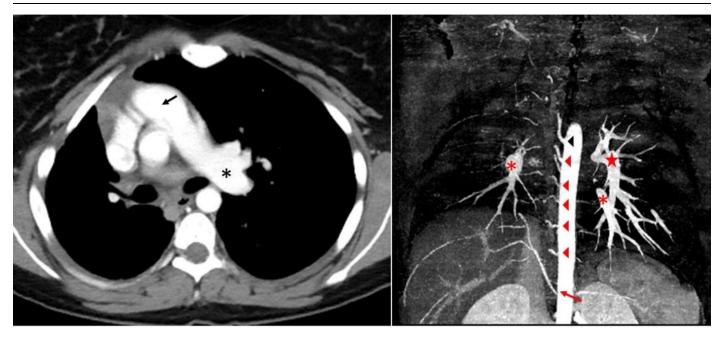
(a) An axial section of a contrast-enhanced CT of the thorax shows a complete absence of the right main pulmonary artery. The solitary left main pulmonary artery (black asterisk) is seen to arise from the pulmonary trunk (black arrow). Note is made of the mediastinal shift to the right. (b) A coronal MIP reformat of the same CT demonstrates systemic arterial feeders from the bronchial artery (black arrowhead), multiple intercostal arteries (red arrowheads) and from the coeliac trunk (red arrow). Both pulmonary veins (red asterisk) are demonstrated but only the left pulmonary artery (red star) is present.
